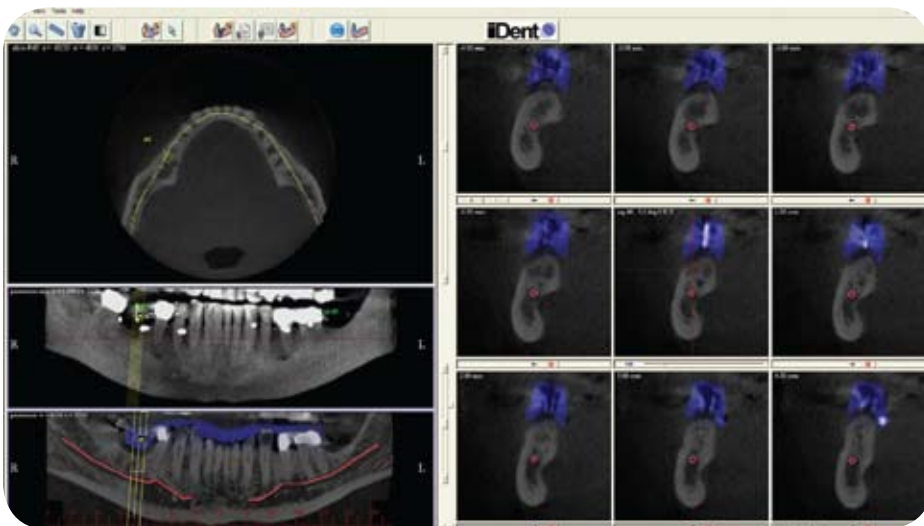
Axial, panoramic, and cross-sectional views of patient's CBCT scan with radiographic guide shown in blue. (Images created in iDent's Scan2Guide software, provided by McCormack Dental Imaging.)
